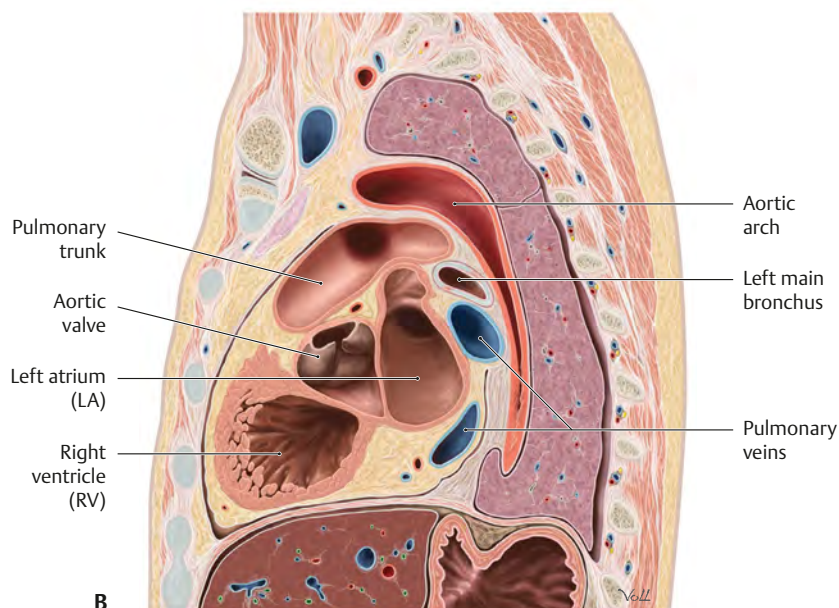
Sagittal section of the heart and similar MRI
